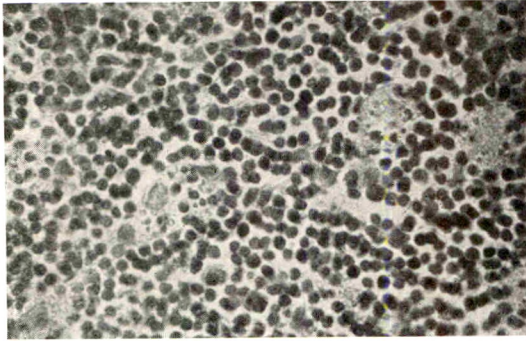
Gland from control side two weeks after a course of ten daily exposures to a medium roentgen dose. Phagocytic cells are not infrequent.
